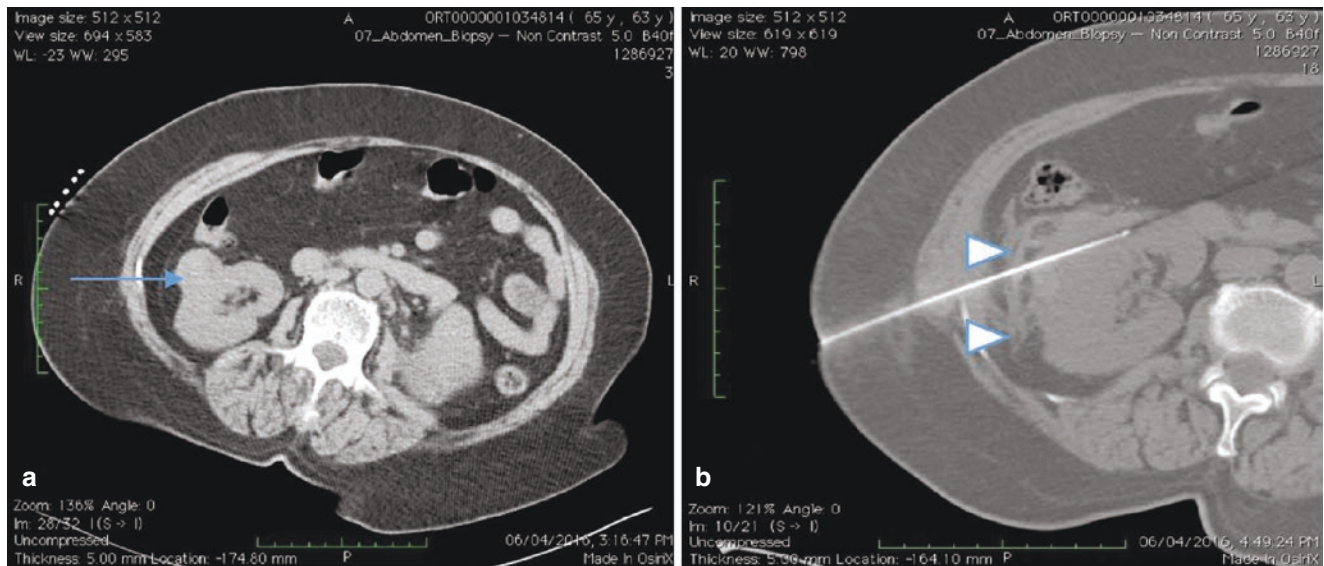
Case of An 82 y.o. female who underwent radiofrequency ablation (RFA). (a) Preoperative imaging shows a 2.7-cm peripherally located, partially exophytic right renal nodule (arrow) surrounded by fat with a safe distance away from the descending colon. A core biopsy that was done prior to the RFA confirmed the diagnosis of renal cell carcinoma, clear cell type. (b) The renal nodule in the interpolar region was accessed under ultrasound and CT guidance using a single G15 Cool-tip needle. The anteroinferior portion of the lesion was first treated for
